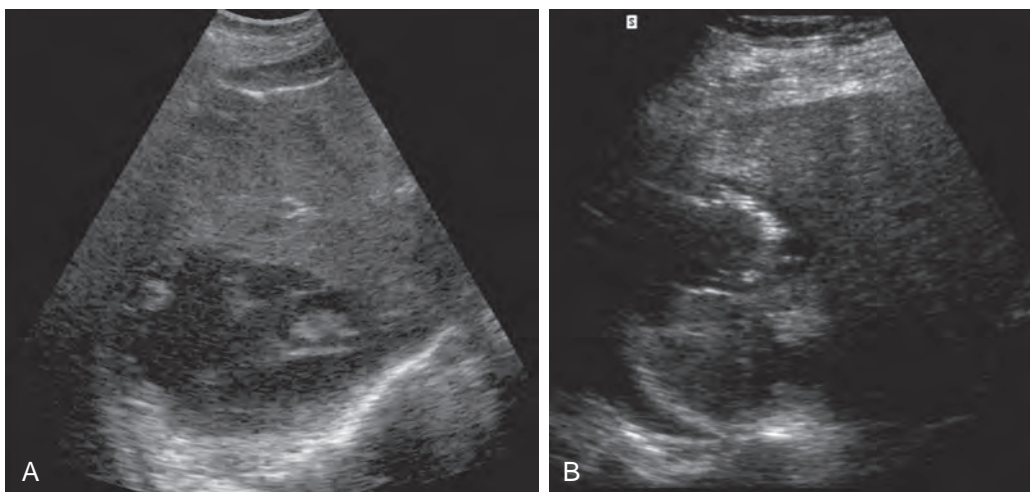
Pyogenic liver abscess: sonographic features. A. Transverse sonogram of the liver shows a complex, predominantly hypoechoic mass with posterior acoustic enhancement containing coarse, clumpy debris. B. Longitudinal sonogram of the liver in a different patient shows bright reflectors within the abscess due to gas.
